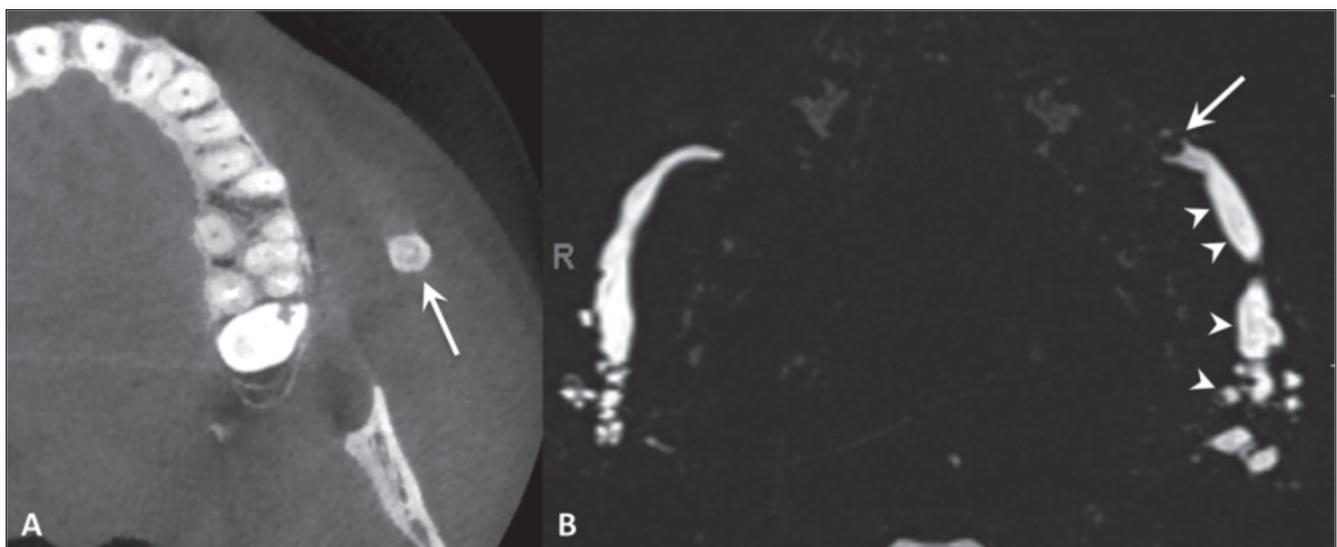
Stensen's duct sialolithiasis. Cone-beam CT (A) and MR sialography (maximum intensity projection in the axial plane) (B). Highly mineralised stone in the left Stensen's duct, corresponding to a filling defect on MR sialography (arrow) causing a marked dilatation of the ductal system (arrowheads); dilatation of the contralateral ductal system is also evident.
